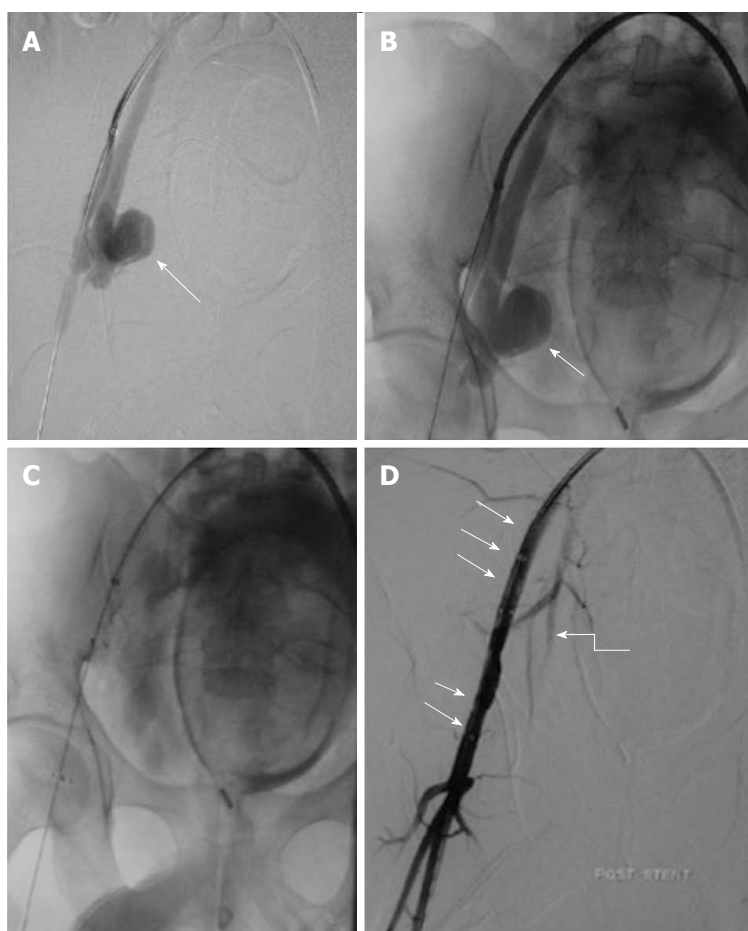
Stent grafting in pseudoaneurysm. Case of gun shot injury, CECT showed presence of PsA from right internal iliac artery (not shown). A, B: Arterial access was obtained through the left common femoral artery and a long arterial sheath was placed. Angiogram showed a large pseudoaneurysm (arrow) arising from the proximal portion of anterior division of right internal iliac artery with no contrast opacification distally (except for a short stump); C, D: Subsequently, a covered stent graft (arrow) was placed in right external iliac artery. Post procedural angiography showed preservation of flow across the right external iliac artery and branches of right internal iliac artery (curved arrow). CECT: Contrast enhanced computed tomography; PsA: Pseudoaneurysm.
